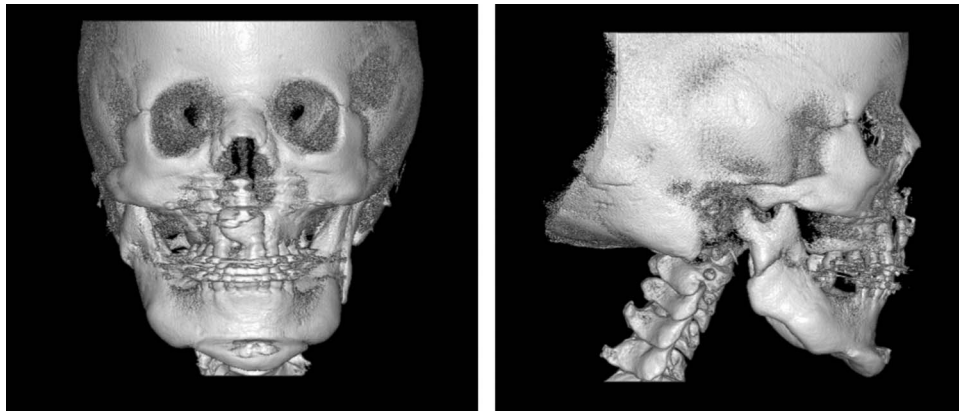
3D computed tomography images taken 1 year after the orthognathic surgery.
